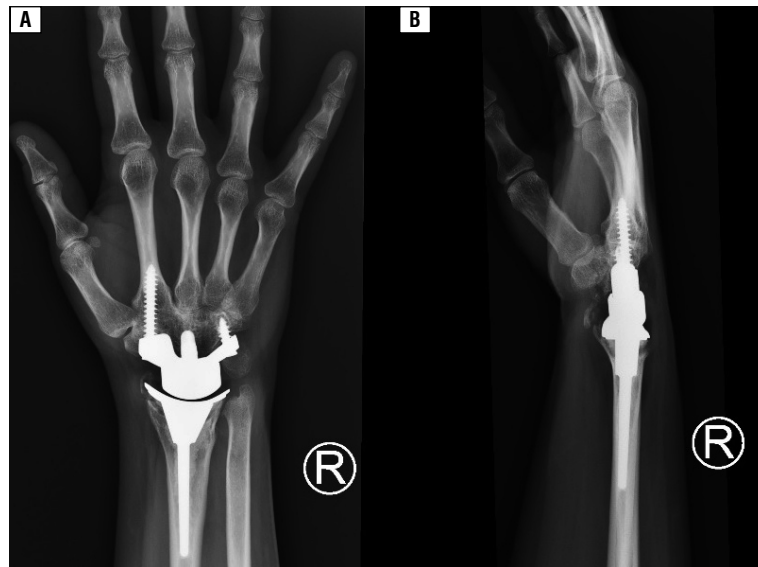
Follow-up (10 years) X-ray of right wrist 4 December 2019: A. Anterior-posterior; B. Lateral
